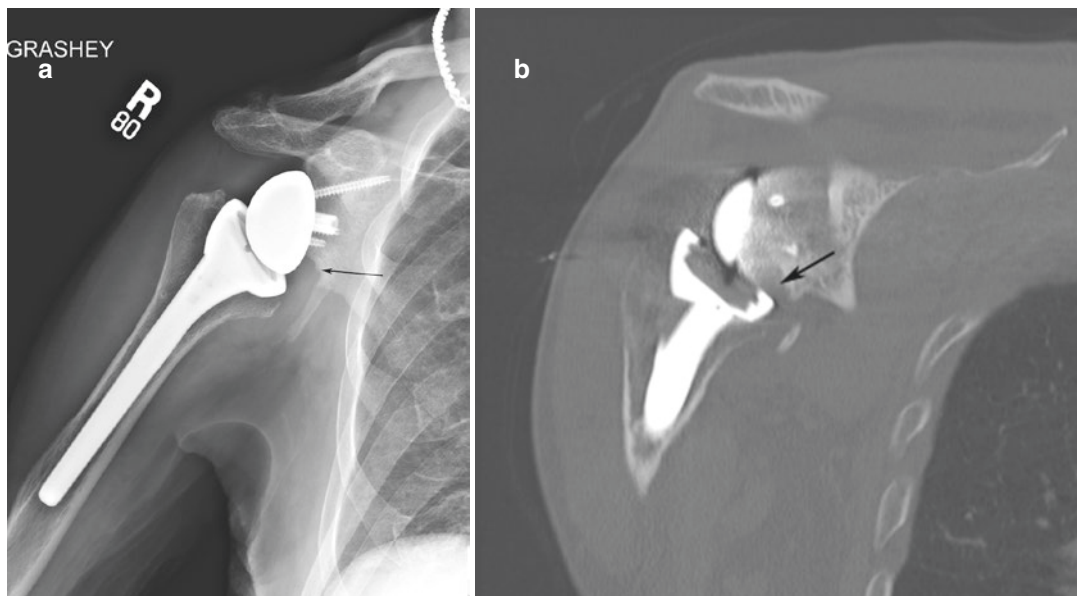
Inferior scapular notching. (a) AP radiograph of a right shoulder RTSA shows notching of the inferior scapular (arrow), better seen on (b) coronal CT image
